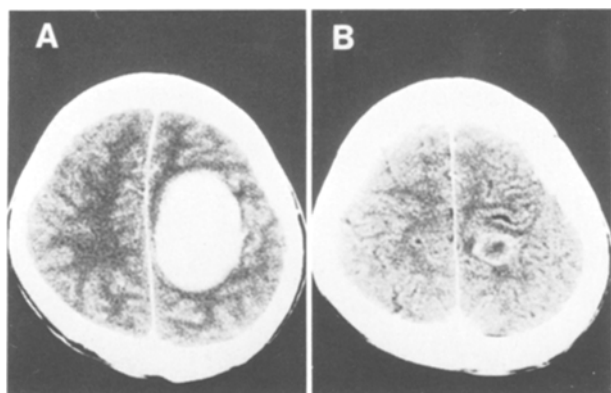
CT scan demonstrating the meningioma involving the motor area of the left hemisphere without perifocal oedema (A). After surgery, the area of surgical removal demonstrated ring-like enhancement on CT scan with infusion of contrast material (B)
